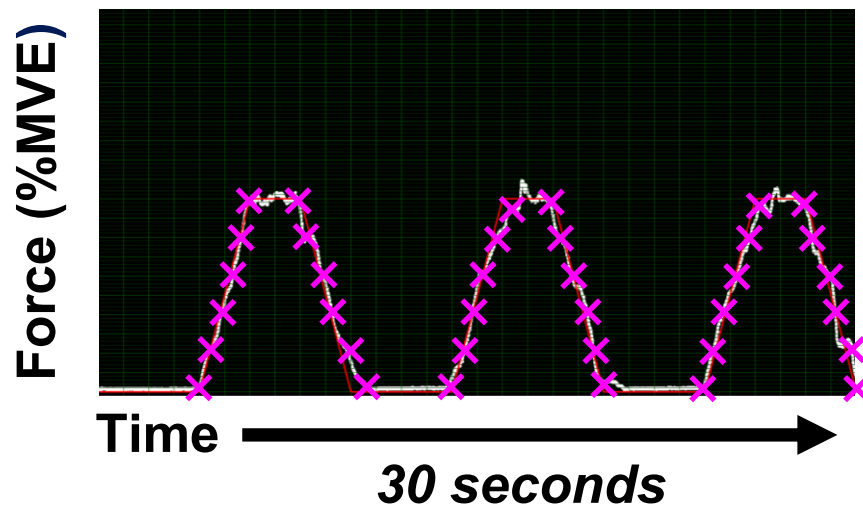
Online display of the force matching task. The X's represent where ultrasound images were extracted along the gripping trials. *Note: Image belongs to the author.*
